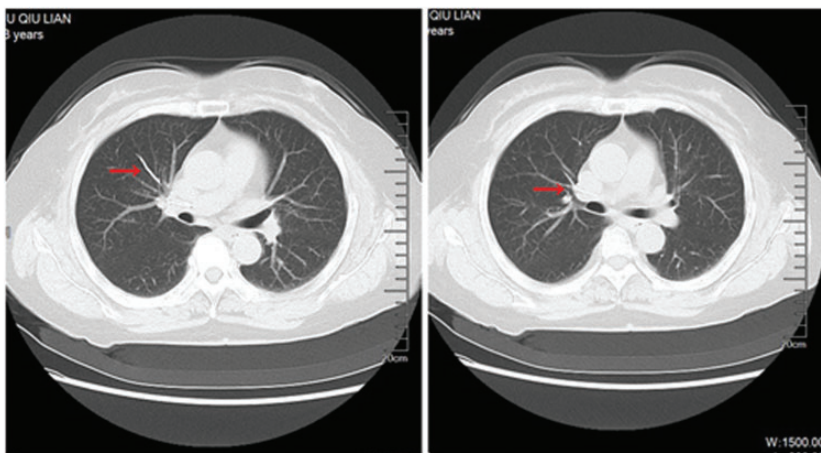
Computed tomography shows another cement leakage that was detected in the right pulmonary artery (red arrows).
